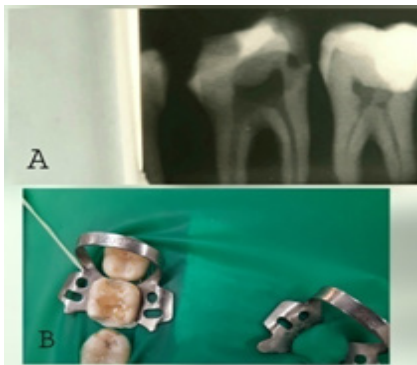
A: Pre-operative X-ray picture - B: Pre-operative intra oral picture
